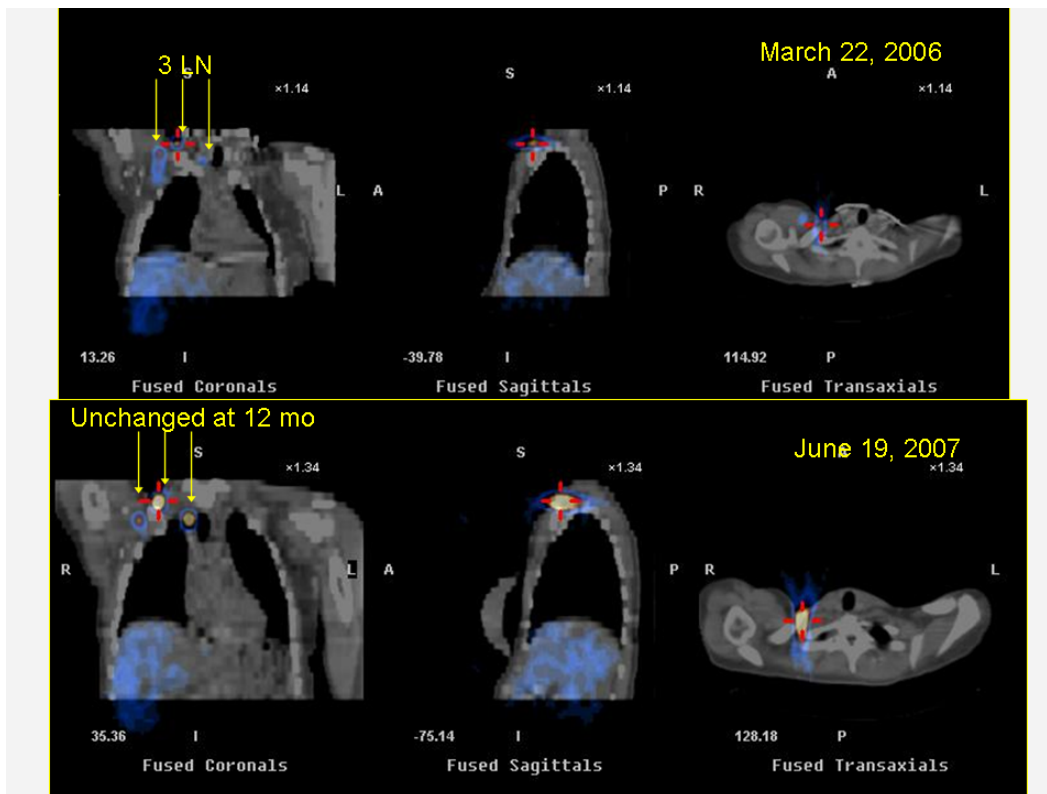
Pre-radiation and follow-up SPECT/CT scan demonstrating sparing of lymph nodes that received $< 40\text{Gy}$.
